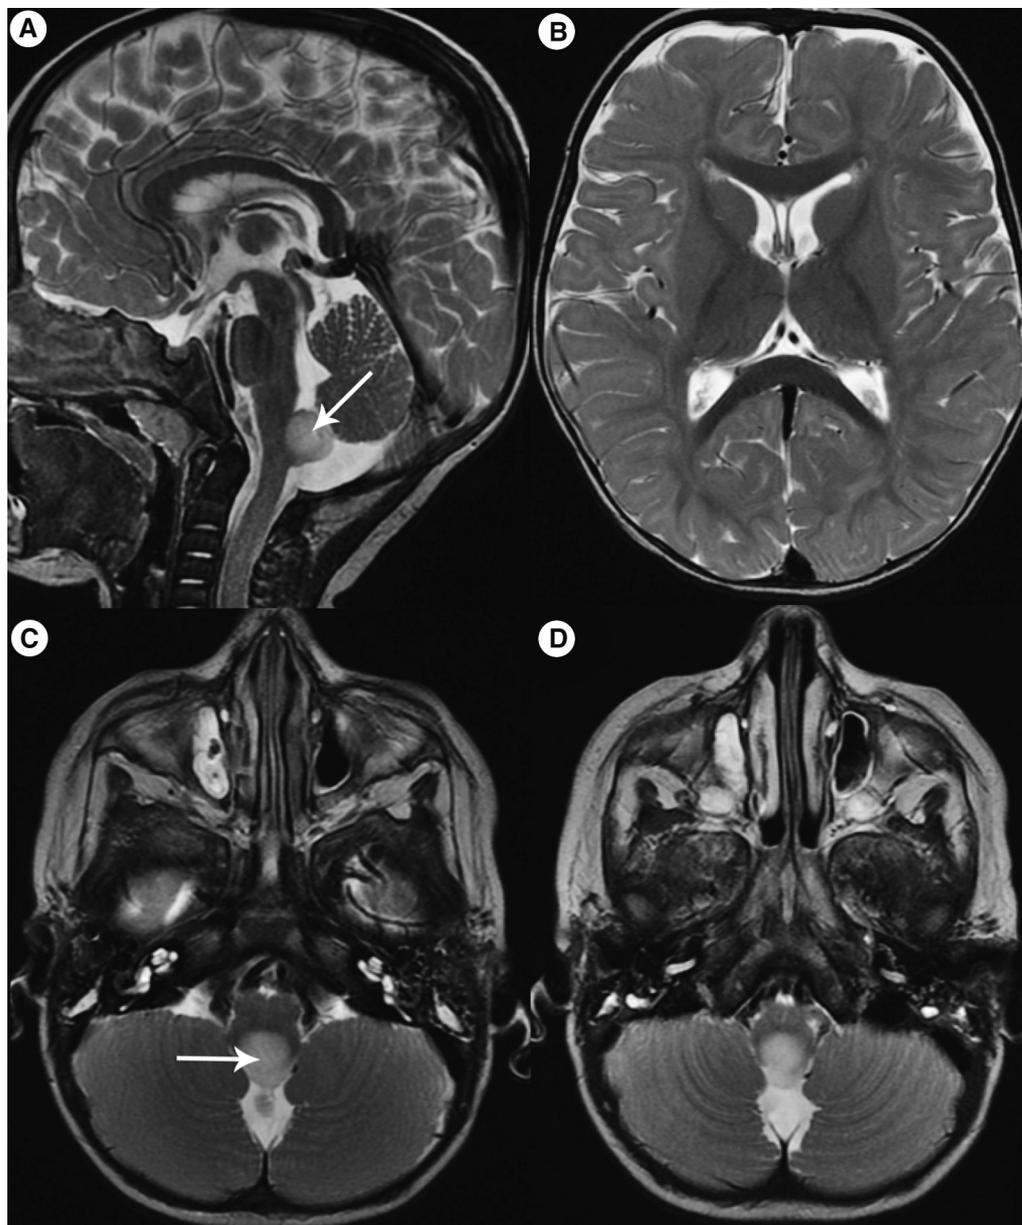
T2 magnetic resonance imaging of nine-month-old infant with primary astrocytoma of area postrema. (A) Sagittal and (C, D) axial T2 images demonstrate a homogeneous noncystic tumor mass (arrows) in the midline of the caudal posterior fossa. It distorts the fourth ventricle but does not obstruct CSF flow. (B) Axial image of supratentorial space shows normal lateral ventricles, confirming absence of obstructive hydrocephalus.
